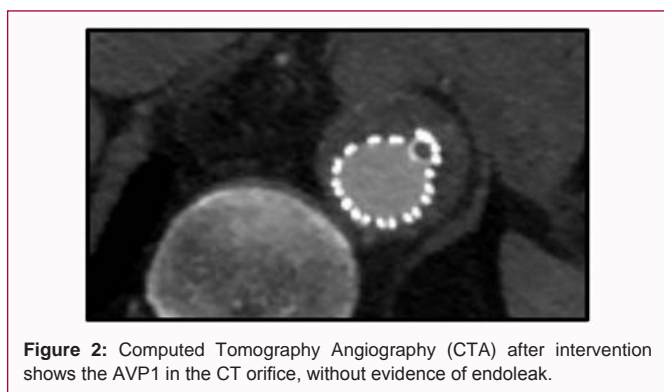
Computed Tomography Angiography (CTA) after intervention shows the AVP1 in the CT orifice, without evidence of endoleak.
